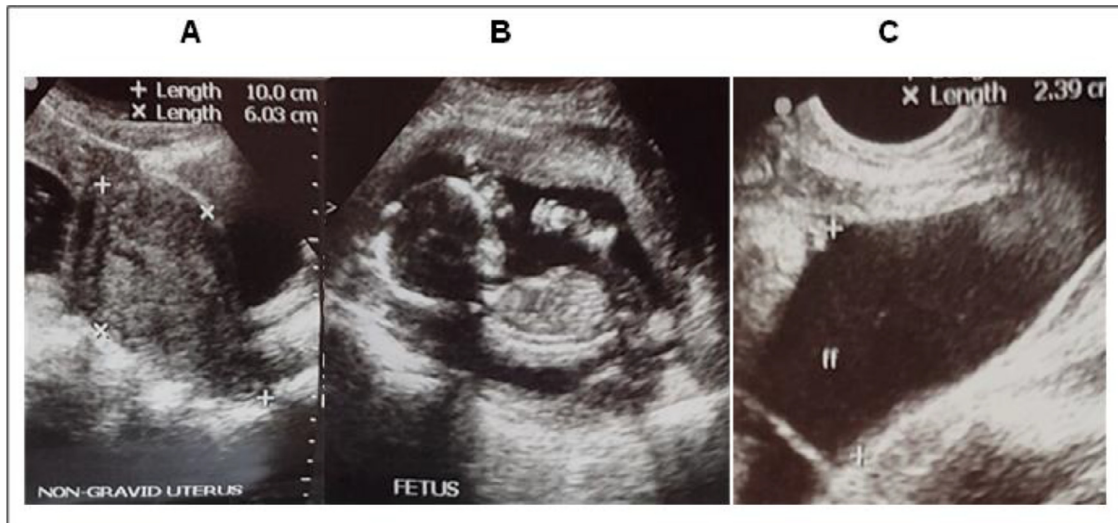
Gray scale ultrasound scan images obtained at 16 weeks gestation show a nongravid uterus (A), an extra-uterine fetus within the abdominal cavity surrounded by reduced amniotic fluid levels (B), and moderate free fluid collection in the posterior cul-de-sac with a depth of approximately 2.4 cm (C).
